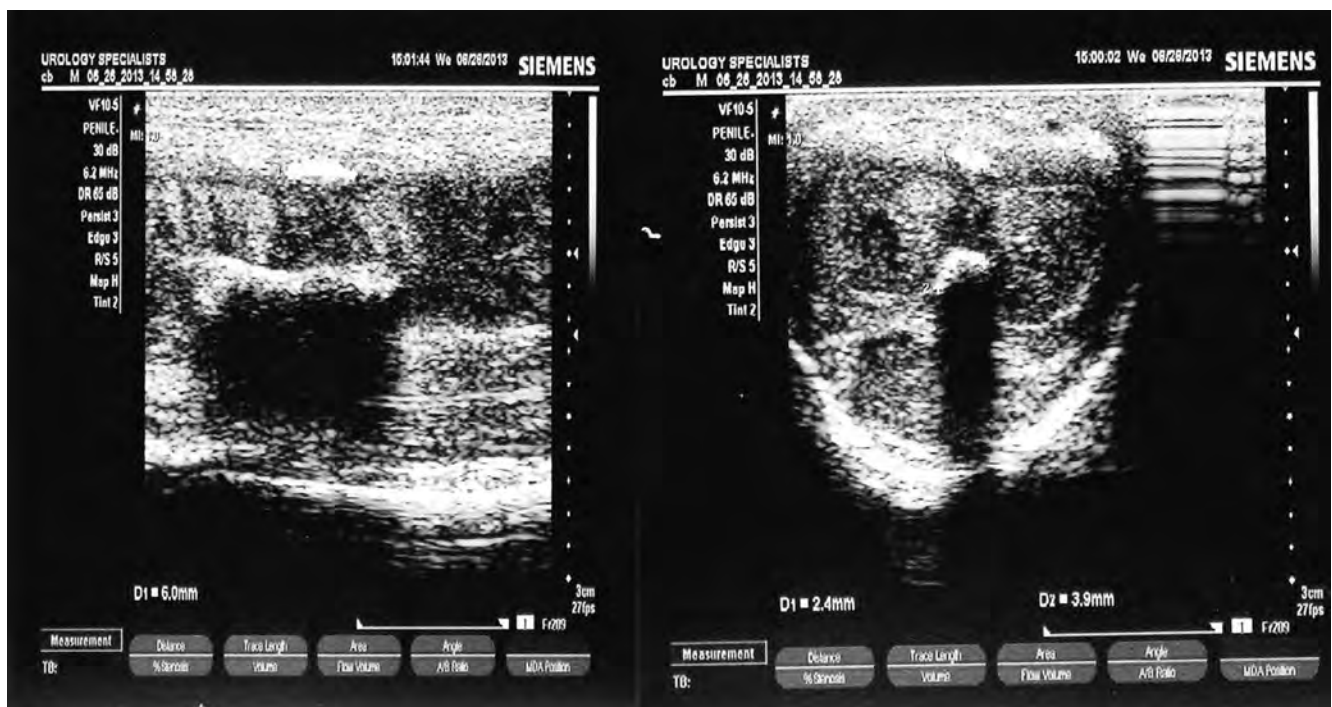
This ultrasound image demonstrates areas of dorsal and ventral calcification. Note shadowing behind calcified plaques.
